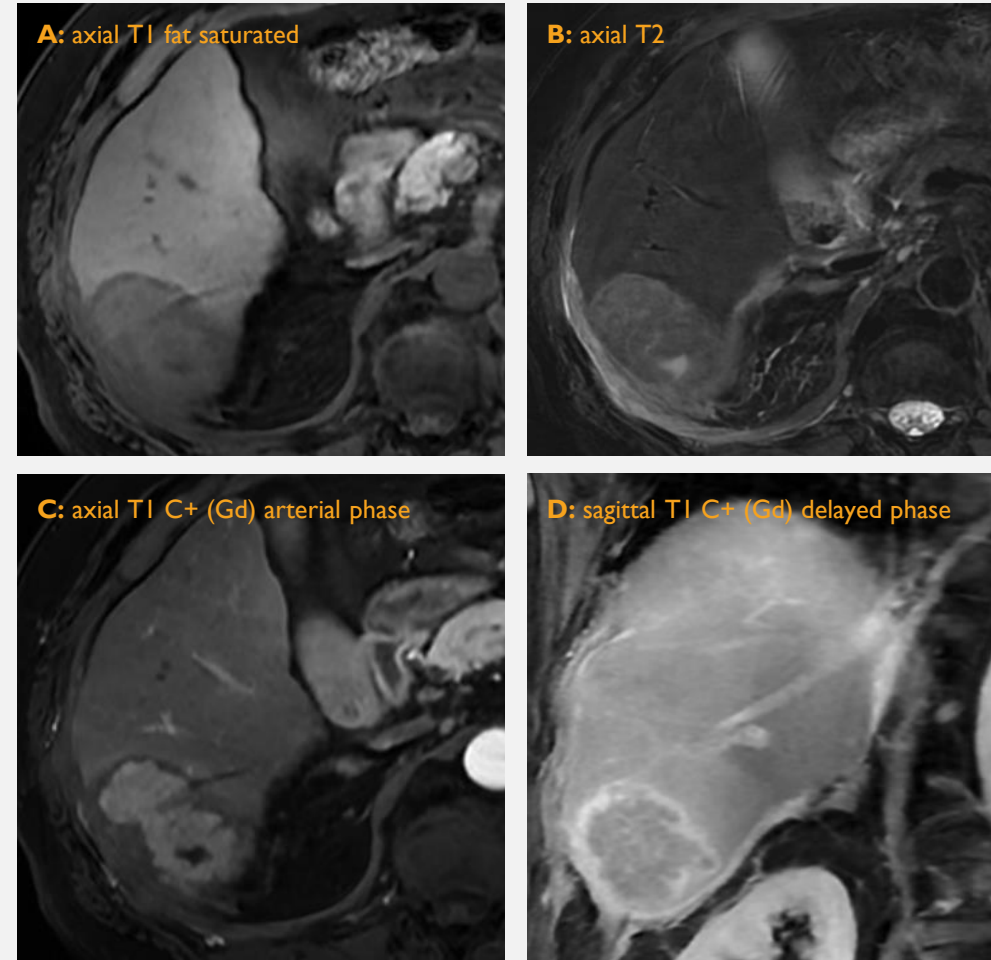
MRI demonstrated a segment 6 liver lesion that was hypointense on fat-saturated T1 sequence (A), mildly hyperintense on T2 (fat saturated) with eccentric cystic areas. (B) The lesion showed intense arterial hyperenhancement (C) with central washout on the delayed phase (D). There was local invasion with capsular breach, pleural involvement with small pleural effusion and corruption of the perinephric soft tissue.
